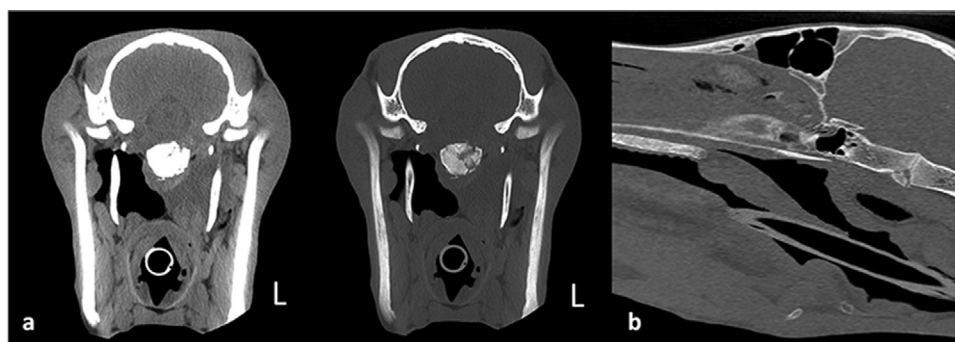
Slices of CT scan study of the head of case 2: (a) transverse views— on the left, the soft tissue algorithm and on the right, the osseous algorithm. The left side of the patient is on the right side of the images; (b) sagittal slice in the bone window. A severely comminuted fracture of the basisphenoid-basioccipital physal junction is observed
